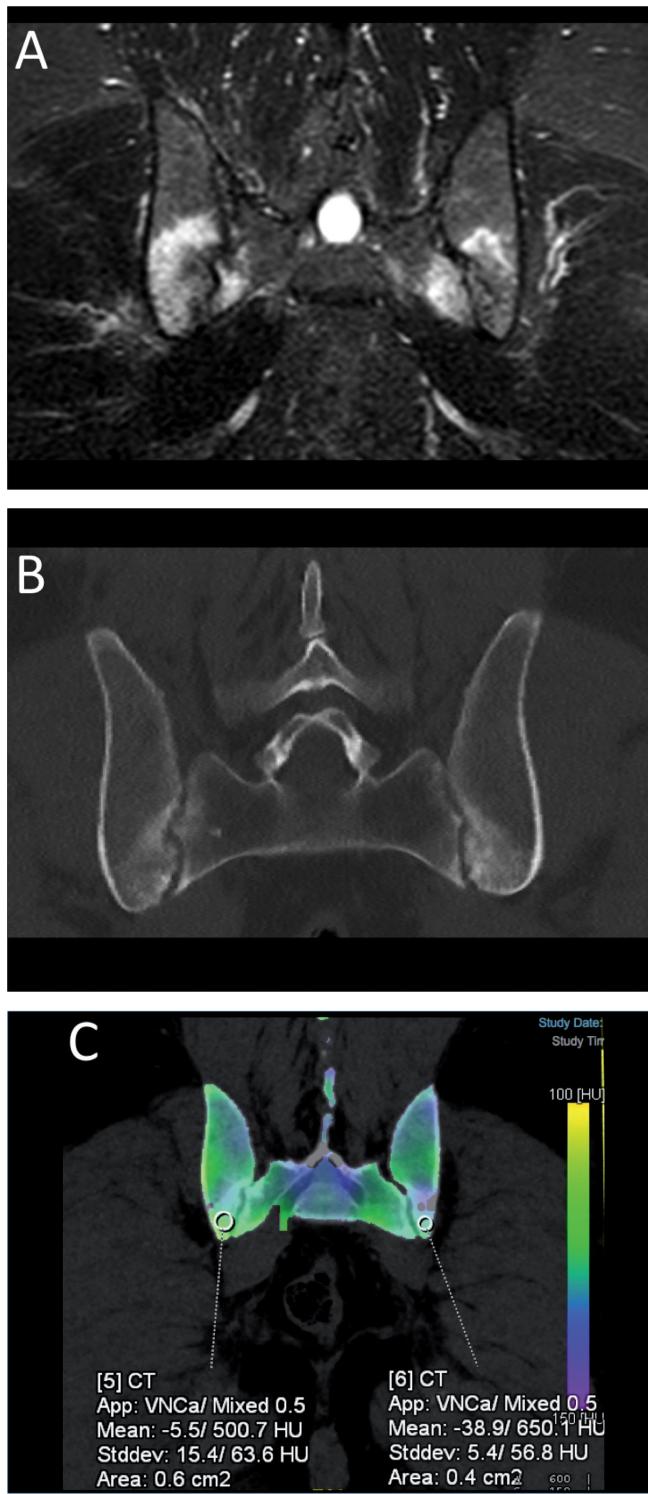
Patient with axial spondyloarthritis. A: Short tau inversion recovery magnetic resonance image in the semicoronal plane demonstrating extensive bone marrow oedema in both iliac and sacral subchondral bone, indicating active sacroiliitis.
